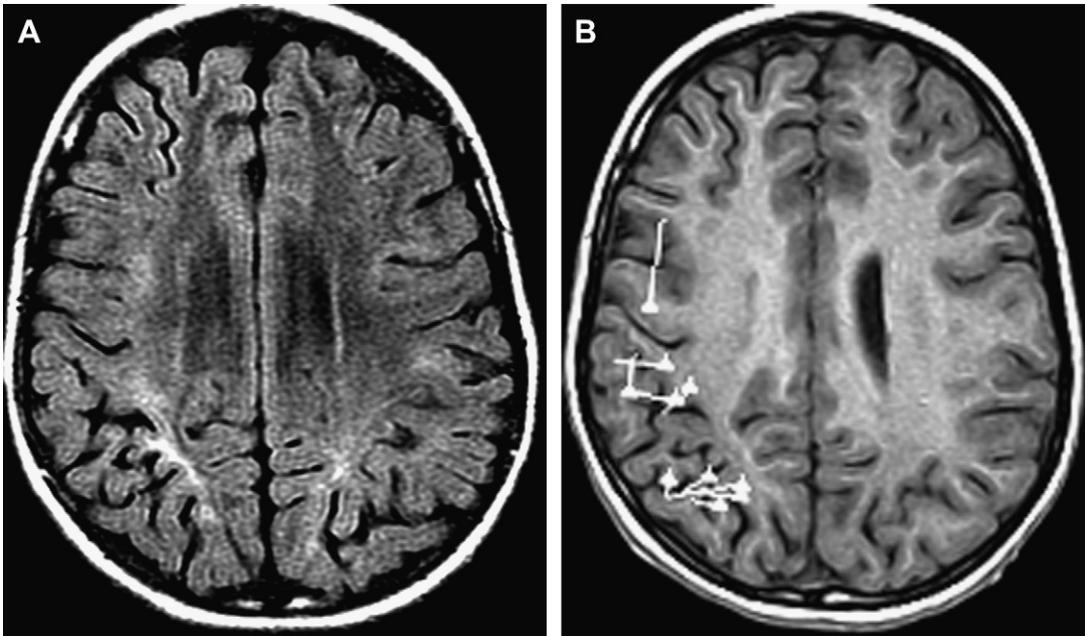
FCD IIID (perinatal hypoglycemic injury). (A) Axial FLAIR. Bilateral parieto-occipital parasagittal bands of gliosis and ulegyria in a child who suffered from a severe hypoglycemia shortly after birth. (B) MEG demonstrated a unilateral, right-sided epileptogenic focus. The child was operated on and an FCD associated with the gliotic scar was demonstrated.
